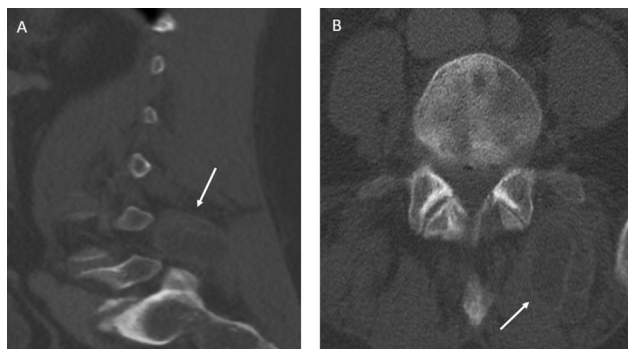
Noncontrast enhanced computed tomography (CT) revealed paravertebral hydatid cyst without eroding bony structure at level L4 and L5. (A) Sagittal view, cyst contour pointed with *white arrow*. (B) Axial view, cyst contour pointed with *white arrow*.
